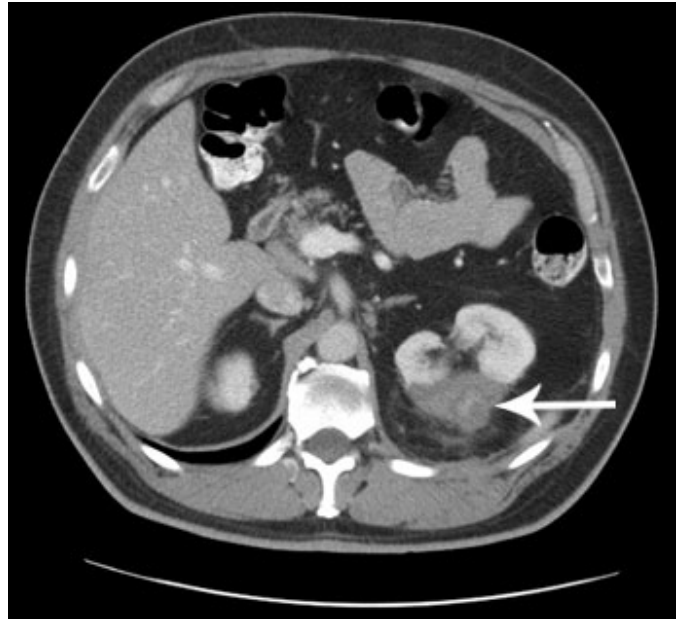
Axial CT at 3 months post ablation shows ablated bed as a non-enhanced wedge shaped area.
